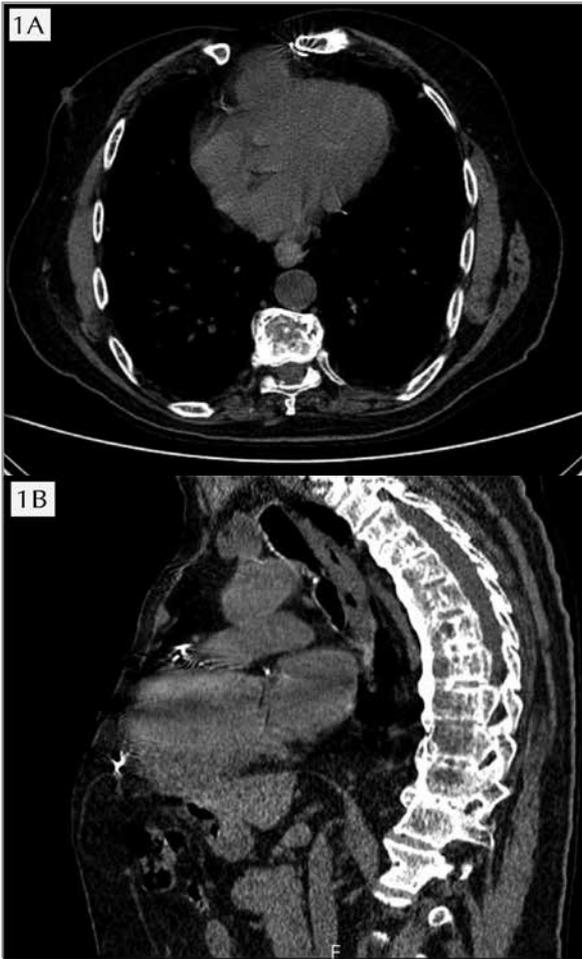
Axial thorax CT (A) and sagittal reformatted image (B) show sternum diastasis and the herniation of the right ventricle.
